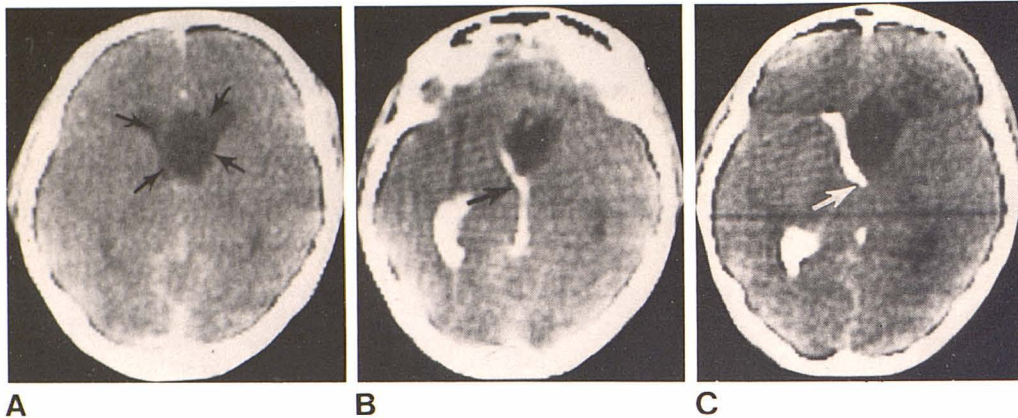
A, Contrast-enhanced CT scan. Oval cerebral spinal fluid density lesion (arrows) in region of septum pellucidum. Dilated anterior horns of lateral ventricles. B and C, Post-Contray ventriculogram CT scans. Filling of right lateral ventricle and third ventricle. Nonfilling left lateral ventricle is identified. Cyst of septum pellucidum anterior to right foramen of Monro (arrows).
